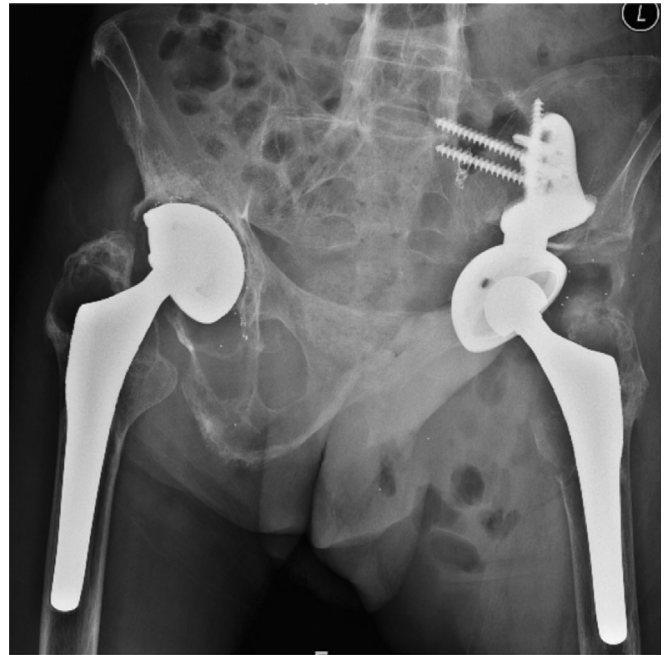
Anteroposterior radiograph after left revision THA.
